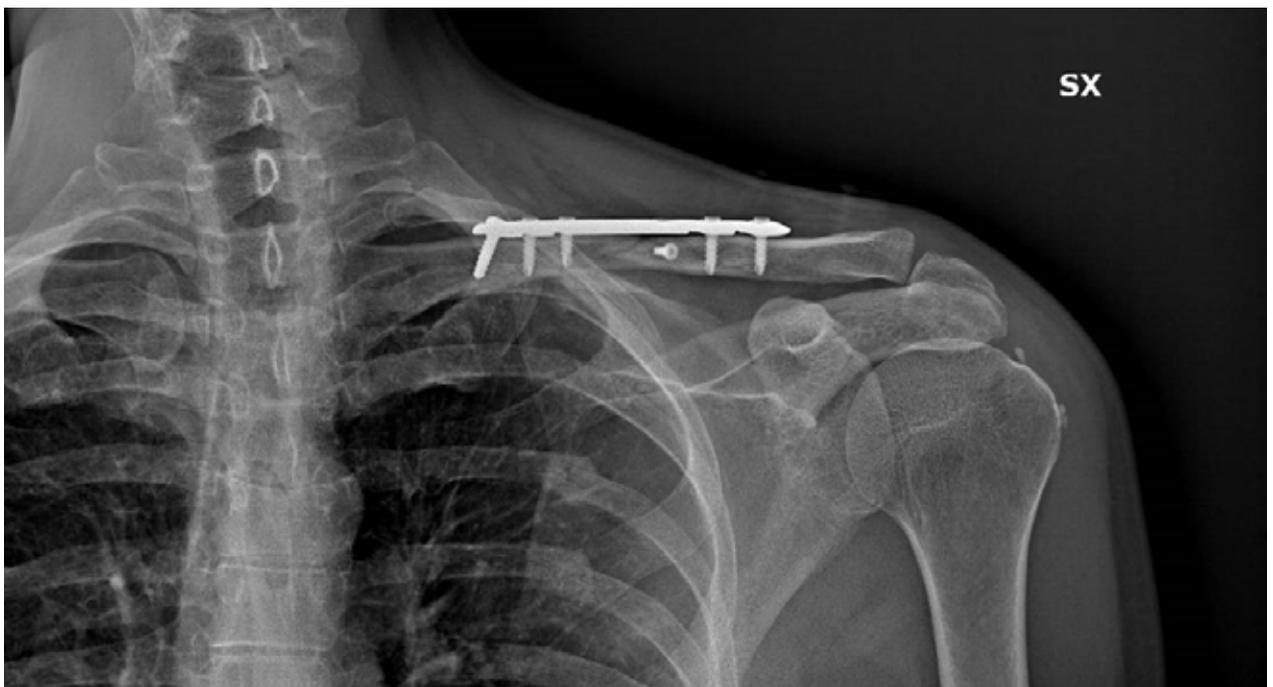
One month post operative radiograph after conical coupling locked plate fixation.
